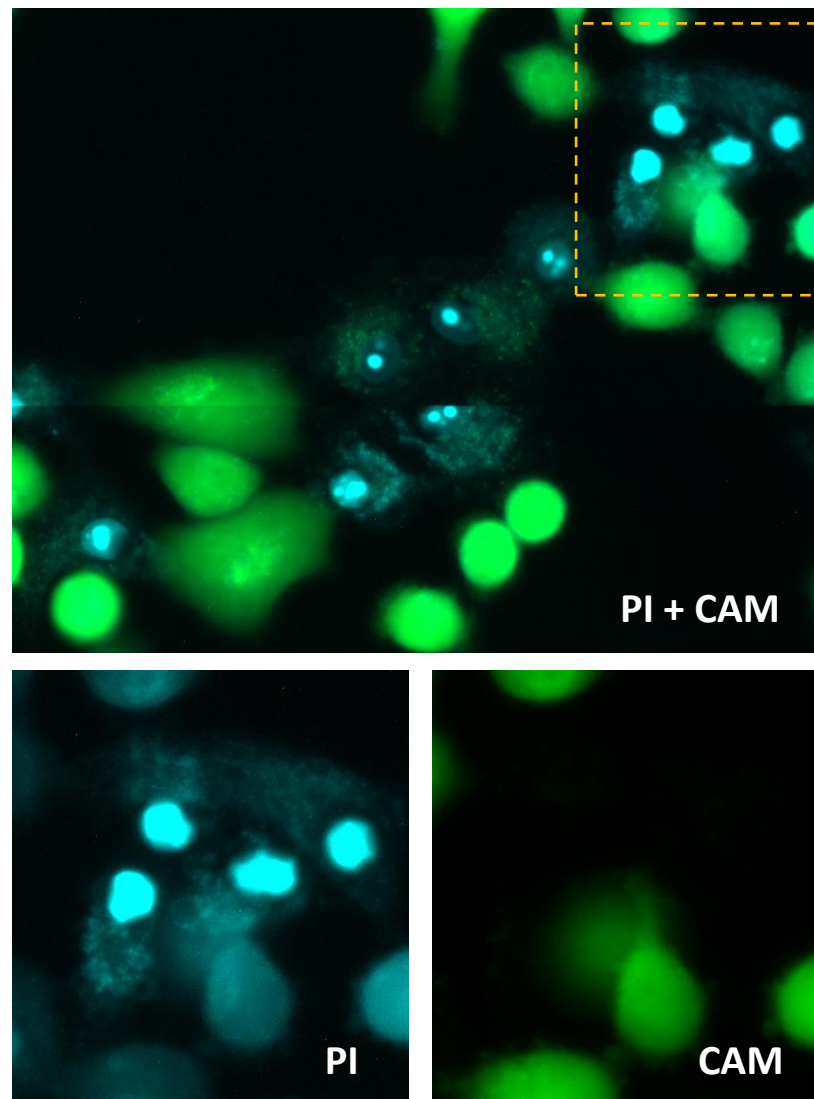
Example of CAM and PI experiment with media incubation after CAM: A549 cells sonicated with PI and MBs ($8 \times 10^6/\text{mL}$ MBs, ultrasound parameters: 250 kPa pk-pk, 30% duty cycle, 100 Hz PRF, 30 sec), washed and incubated for 10 mins in DPBS with CAM, washed and incubated for 10 mins in cell media (see Methods). Green indicates CAM, cyan – PI, no cell mask shown;
